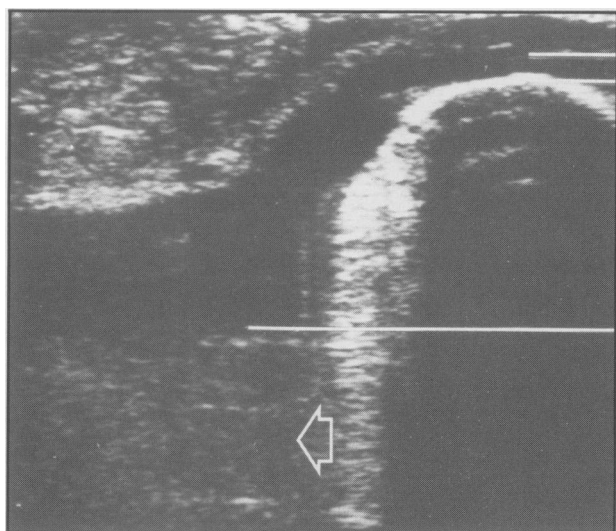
Ultrasonogram obtained transrectally with a 5.0 MHz linear rectal transducer of a longitudinal section through the dilated urinary bladder of a ram with obstructive urolithiasis. Urethra and urinary bladder are dilated. The urinary bladder cannot be fully imaged in its ventral region because of its large diameter. Notice the numerous weak echoes in the ventral part of the urinary bladder (arrow). Top line = urethra; second line = pelvic floor; bottom line = urinary bladder.
